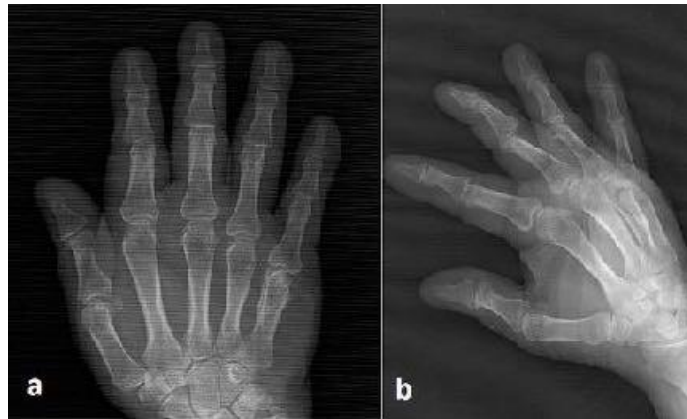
Prereduction x-rays
